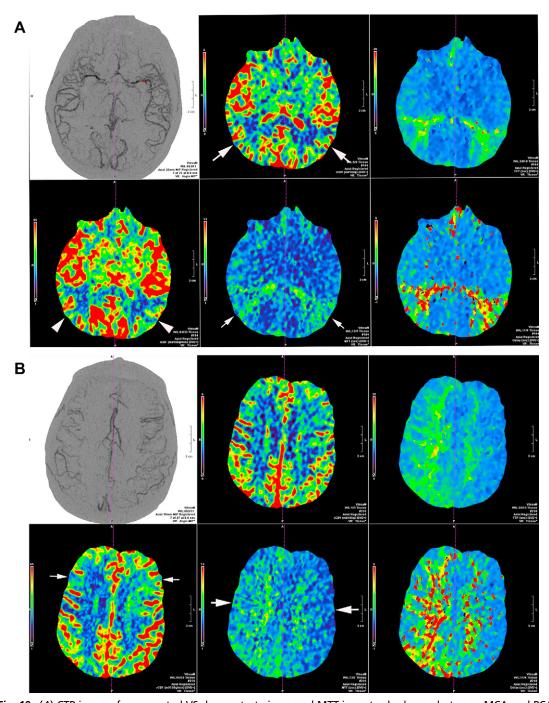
(A) CTP images for suspected VS demonstrate increased MTT in watershed zone between MCA and PCA territory (arrows in middle lower image) with corresponding decreased rCBF (arrowheads in left lower image) and matched defect on rCBV (arrows in middle upper image). (B) CTP images from same study at slightly higher level shows increased MTT in large area of right MCA distribution compared with left (middle lower image) suggestive of VS and ischemia. rCBF shows lower values (arrows in left lower image) corresponding to already infracted watershed zone between anterior and middle cerebral artery. Subsequent DSA (C) demonstrates the expected significant spasm in right distal ICA and proximal MCA and ACA that was treated with intra-arterial nicardipine and balloon angioplasty. Posttreatment DSA (D) shows significant improvement in vessel caliber along with clinical improvement. Noncontrast CT image (E) obtained a few days later only showed watershed infarcts that were initially noticed during CTP images. Further infarcts were prevented using timely intervention.
